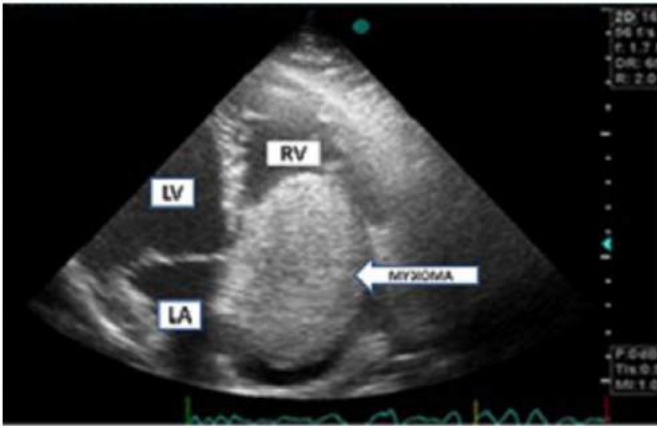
Transthoracic echocardiography revealed a mass almost completely fill the right atrium prolapsing through the tricuspid valve into right ventricle.
